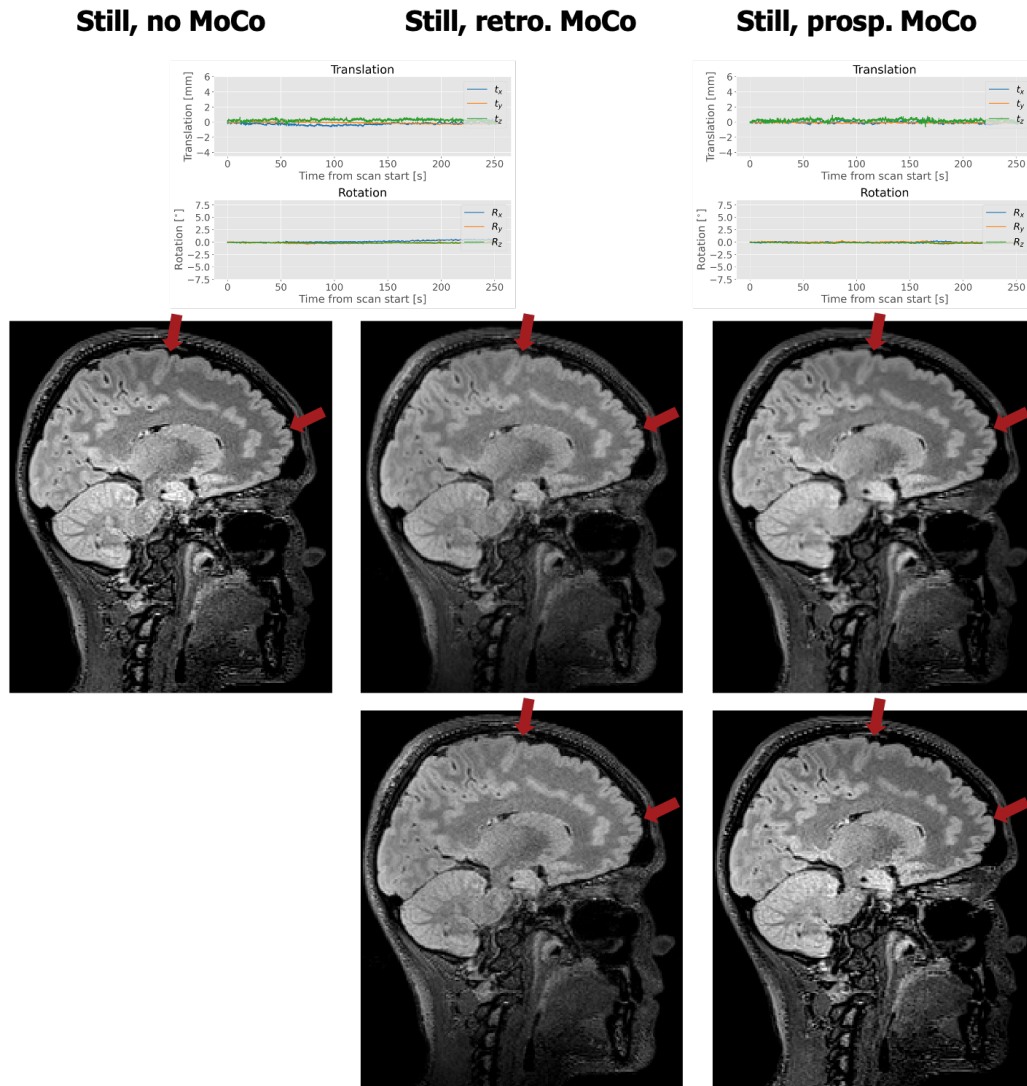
Exemplary T<sub>2</sub> FLAIR images, comparing the still scans for all motion correction settings. Images in the first row are registered to the still, uncorrected scan. Images in the second row are not registered, in order to examine the effects without interpolation related smoothing. The differences between the individual images are quite small and difficult to appreciate in individual slices next to each other. However, red arrows indicate regions, where white and grey matter boundaries for the prospectively corrected scan are slightly more blurry than for the other two scans. This effect is reduced, when comparing unregistered images. However, not all blurring can be explained by interpolation. The corresponding motion curves are shown above the images. Since rMC was applied to the uncorrected scans, the motion curve in the middle corresponds to both images.
